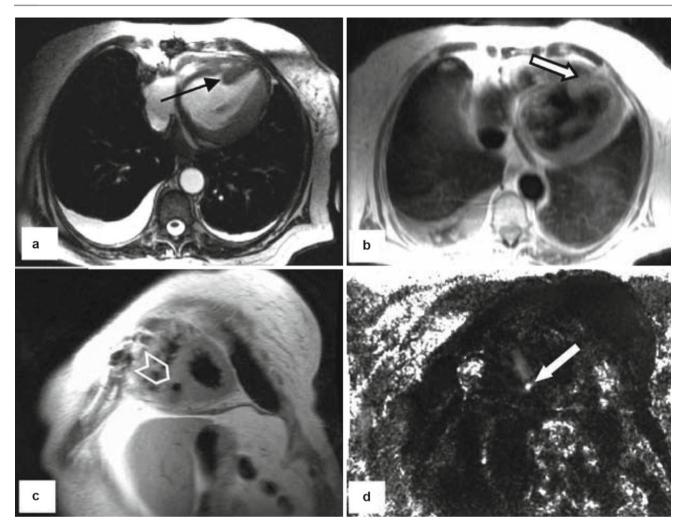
A 54-year-old female with progressive dyspnea 6 month following an anterior septal MI. A murmur was heard prompting an MRI evaluation. (a) A septal defect in the interventricular myocardium is seen (*arrow*). (b) The high-velocity flow between the LV and RV was diagnostic of a post-infarct VSD (*arrow*). (c) Selective breath-hold
